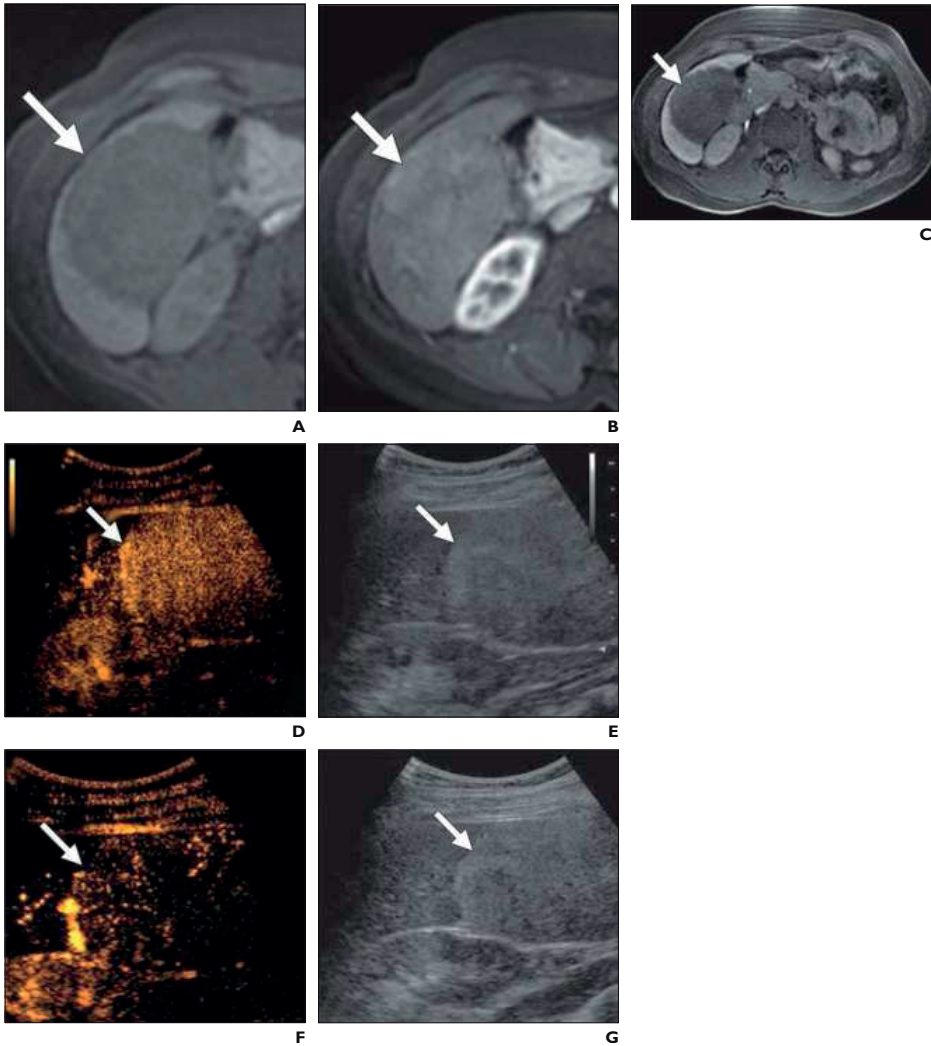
41-year-old-woman with focal liver lesion who underwent contrast-enhanced sonography and MRI with liver-specific contrast agent; findings were concordant for hepatocellular adenoma. A–C, Images from MRI with liver-specific contrast agent show solitary lesion in liver segments V and VI (arrow, A–C). Lesion is hypointense on T1-weighted fat-saturated image (diffuse fatty content of lesion) (A), shows enhancement on arterial phase image obtained after IV contrast administration (B), and shows marked signal hypointensity on delayed hepatobiliary excretory phase image (C). Findings suggest adenoma of hepatocyte nuclear factor 1α - mutated subtype. D–G, Contrast-enhanced sonography images show hyperechoic homogeneous lesion with centripetal contrast enhancement (arrow, D and F) and with no washout and no retainment of contrast agent (arrow, E and G). Findings are concordant with MRI findings, resulting in confident diagnosis of adenoma.
